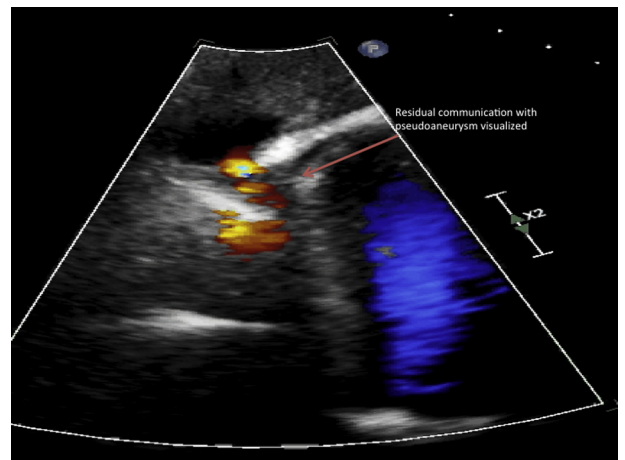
Color Doppler image; the arrow points toward the residual communication with the pseudoaneurysm measuring 0.6 cm in length from a midesophageal view.
